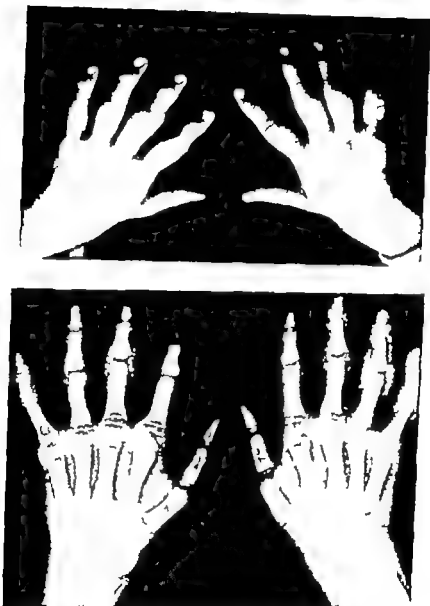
Syphilitic dactylitis in a boy aged 3 $\frac{1}{2}$ years. The clinical photograph demonstrates the soft tissue swellings, but no bone or joint changes are discernible by X-rays. The patient's symptoms began with swelling of the knees and interstitial keratitis at the age of 2 $\frac{1}{2}$ years. At 8 years of age the fingers were almost well and no bone or joint changes were seen by X rays. Still called the condition "pseudo-osteo-arthritis" (Sir Frederick Still's patient)
